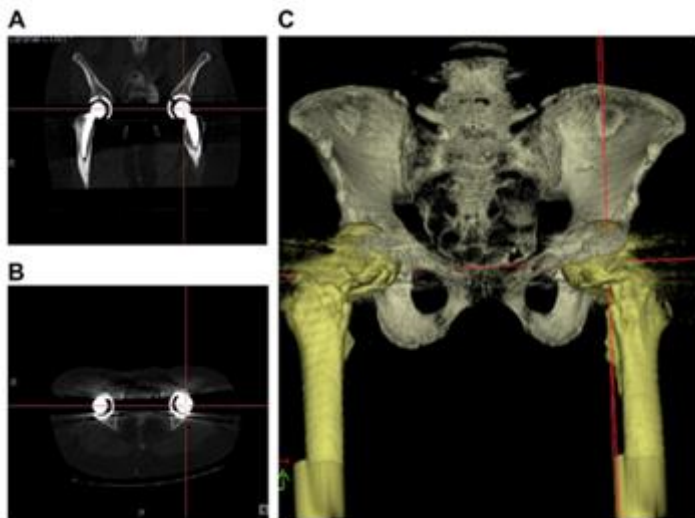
This figure shows the 3D CT-model analysis for acetabular cup orientation. (A) A frontal view from the post-operative CT scan of the pelvis and proximal femur.(B) A transverse view from the post-operative CT scan of the pelvis and proximal femur. (C)A 3D pelvis–prosthesis model constructed from the CT images. (Courtesy of Lin et al [9])
